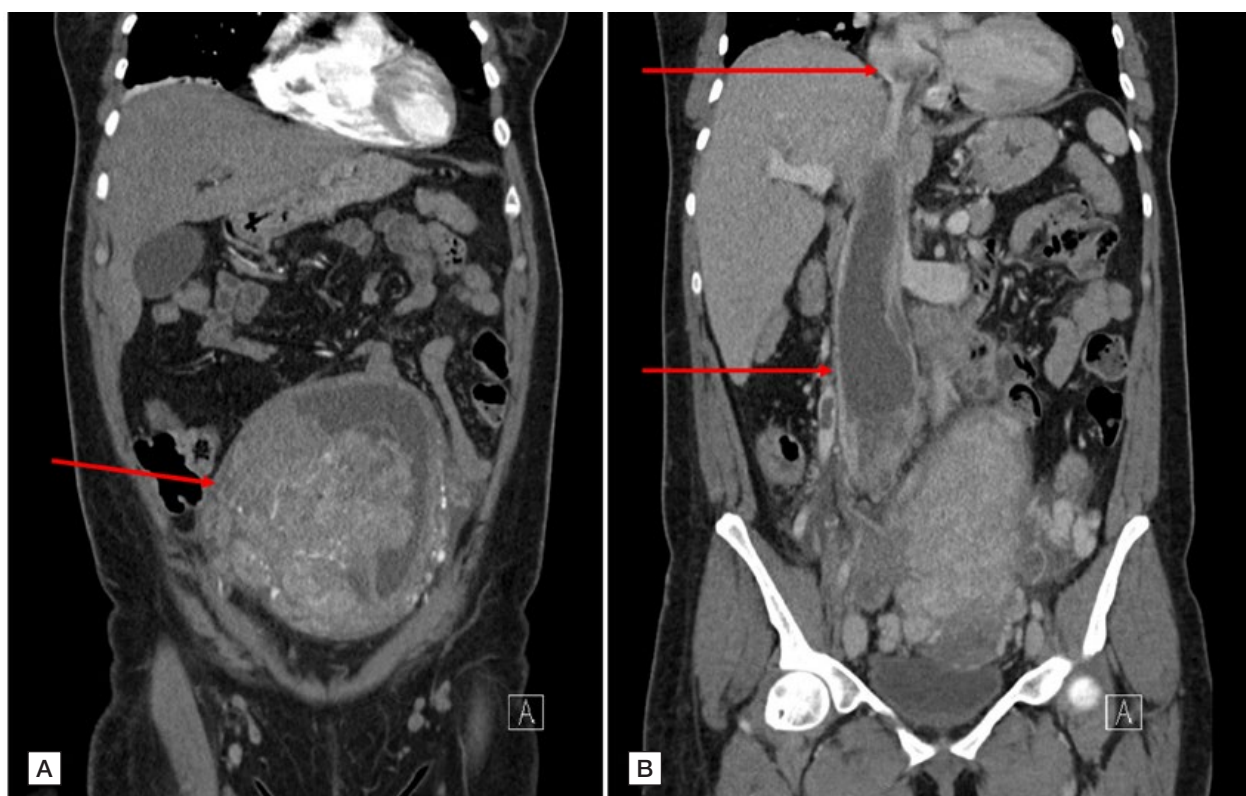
[A] Preoperative coronal computed tomography of the abdomen and pelvis, showing an advanced gynaecological tumour (arrow). [B] Preoperative coronal computed tomography of the abdomen and pelvis, showing an irregular intravascular filling defect due to a tumour invading the inferior vena cava and extending into the right atrium (arrow).
